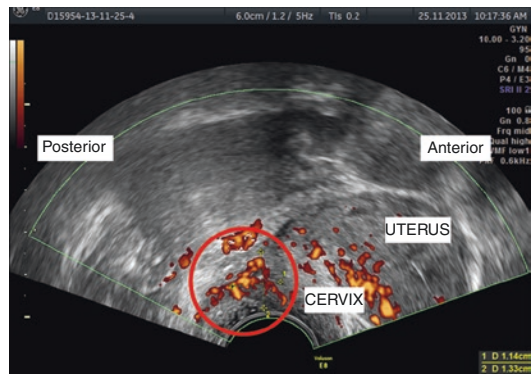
A solid forniceal nodule as visualized using transvaginal ultrasonography and power Doppler
